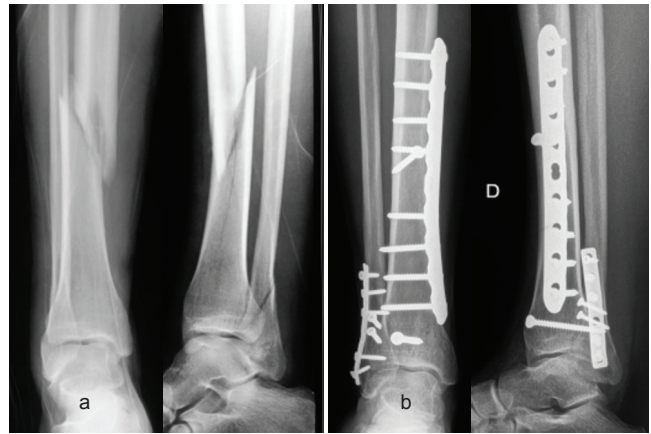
Example of primary healing of a tibia fracture. (a) Pre-op X-rays of tibia and fibula fracture. (b) Control X-rays at 1 year: rigid plate fixation and primary healing.
